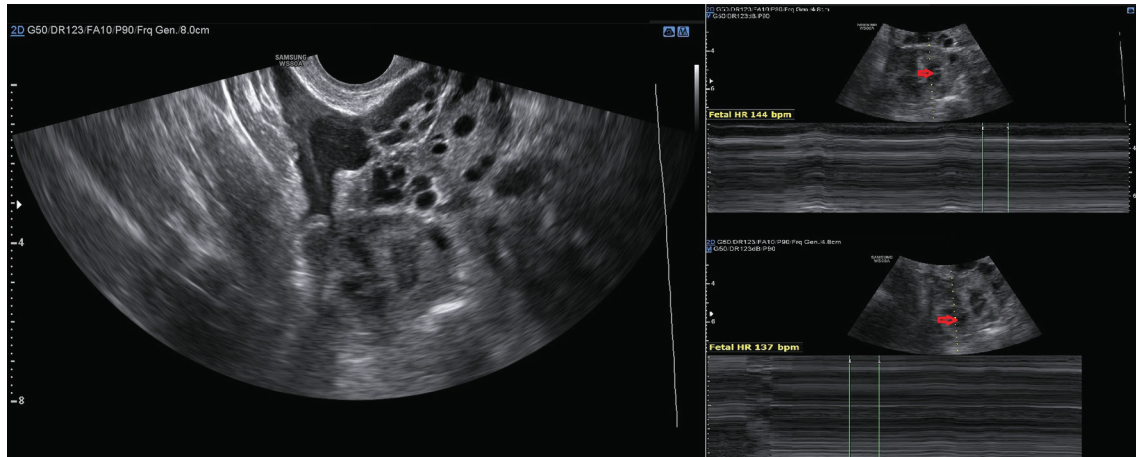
Transvaginal ultrasound showed left adnexal mass containing live twin ectopic pregnancies in separate gestational sacs. Red arrows show the two live fetuses within the mass of ectopic pregnancy.
